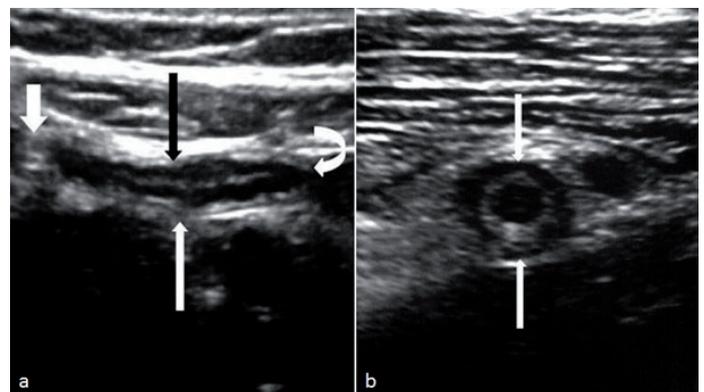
Sonograms of a normal appendix. a. Longitudinal section of a normal appendix (white and black arrows). Criteria for the visualization of a normal appendix include a continuing vermiform appendix from the cecum (white thick arrow) and a blind ending of the appendiceal tip (curved arrow). b. Round transverse section of a normal appendix (white arrows).
